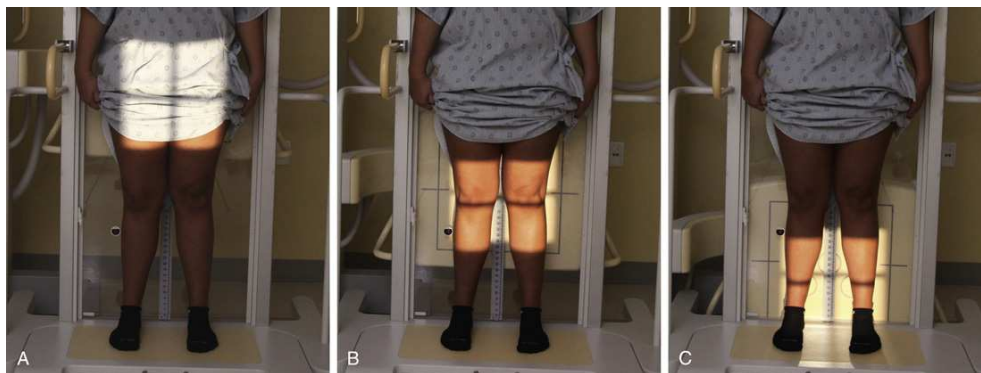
Upright leg measurement procedure. Three radiographs are taken. (A) The first includes the hips; (B) the second includes the knees; (C) the third includes the ankles.
